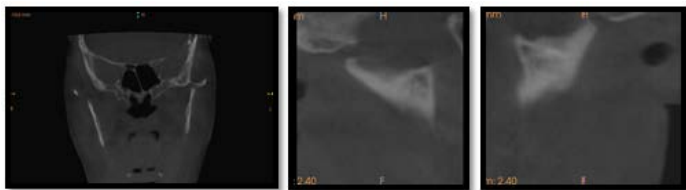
A coronal section of CBCT showing a significant reduction in the mediolateral width of the condyle on right and left side.
